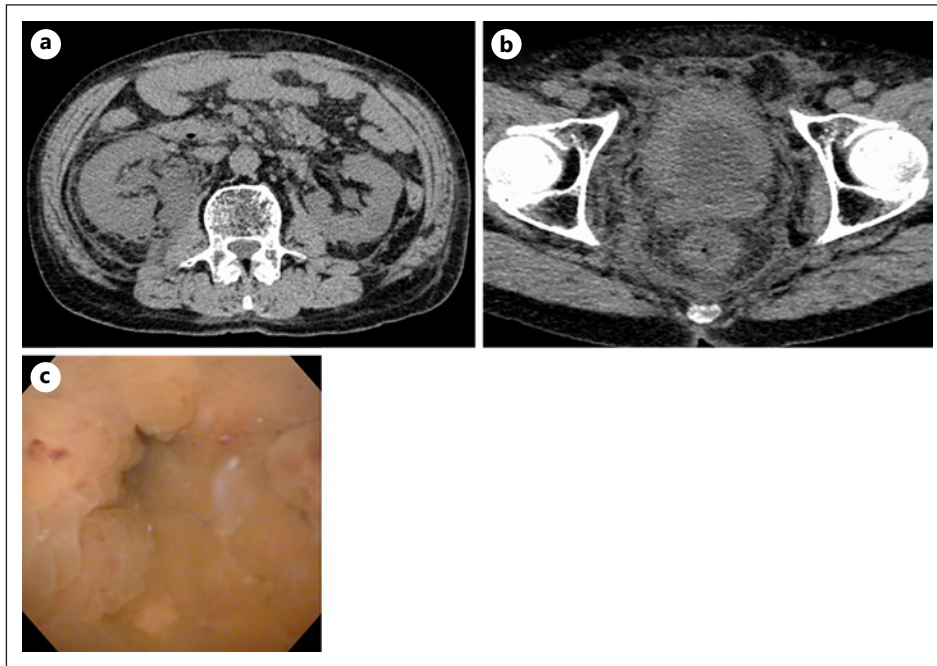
Results of abdominal CT (a, b) and cystoscopy (c) at the initial diagnosis. CT shows bilateral hydronephrosis (a) and diffuse thickening of the bladder wall and suspicious to inflammation at retroperitoneal space (b). c Cystoscopy reveals the whole bladder mucosa is edematous change so that an atypical bladder tumor unlike conventional UC is suspected.
